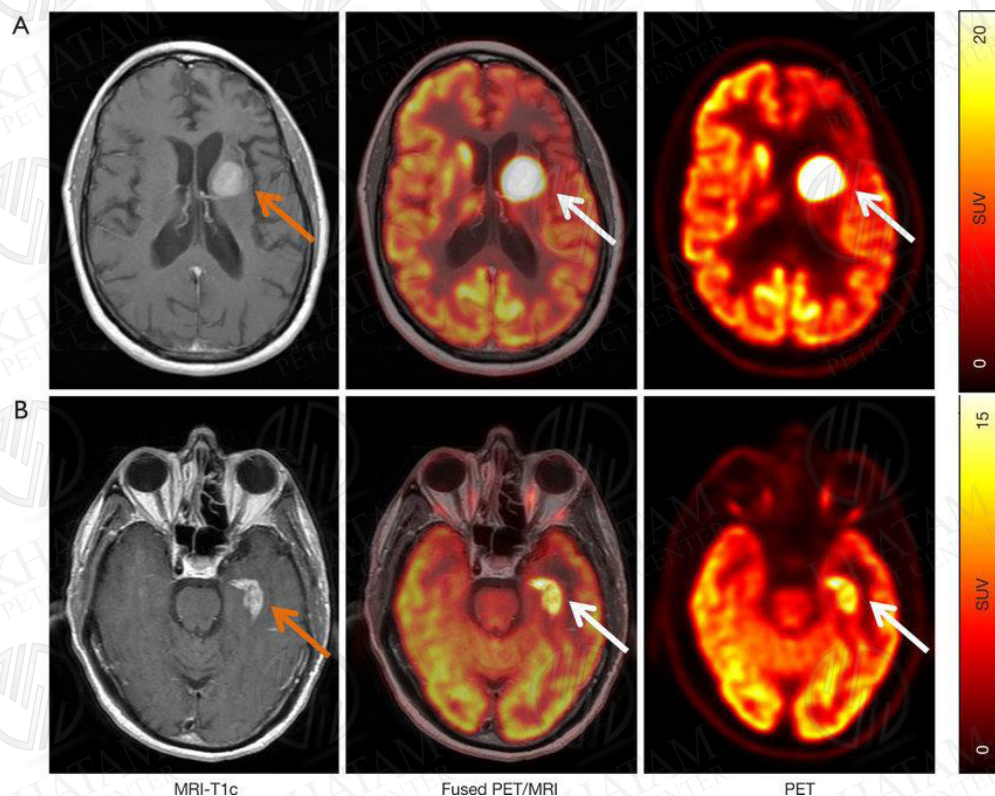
Representative cases of primary CNS lymphoma on FDG PET and MRI. (A) Contrast-enhanced T1-weighted MRI shows an enhancing lesion (left, orange arrow) in left corona radiata and superior basal ganglia, which demonstrate focal ^{18}F -FDG uptake on axial fused PET/MRI (middle, white arrows) and PET images. (B) Contrast-enhanced T1-weighted MRI depicts an enhancing lesion (left, orange arrow) at the left temporal horn; fused PET/MRI (middle, white arrow) and PET images confirmed focal ^{18}F -FDG uptake.
